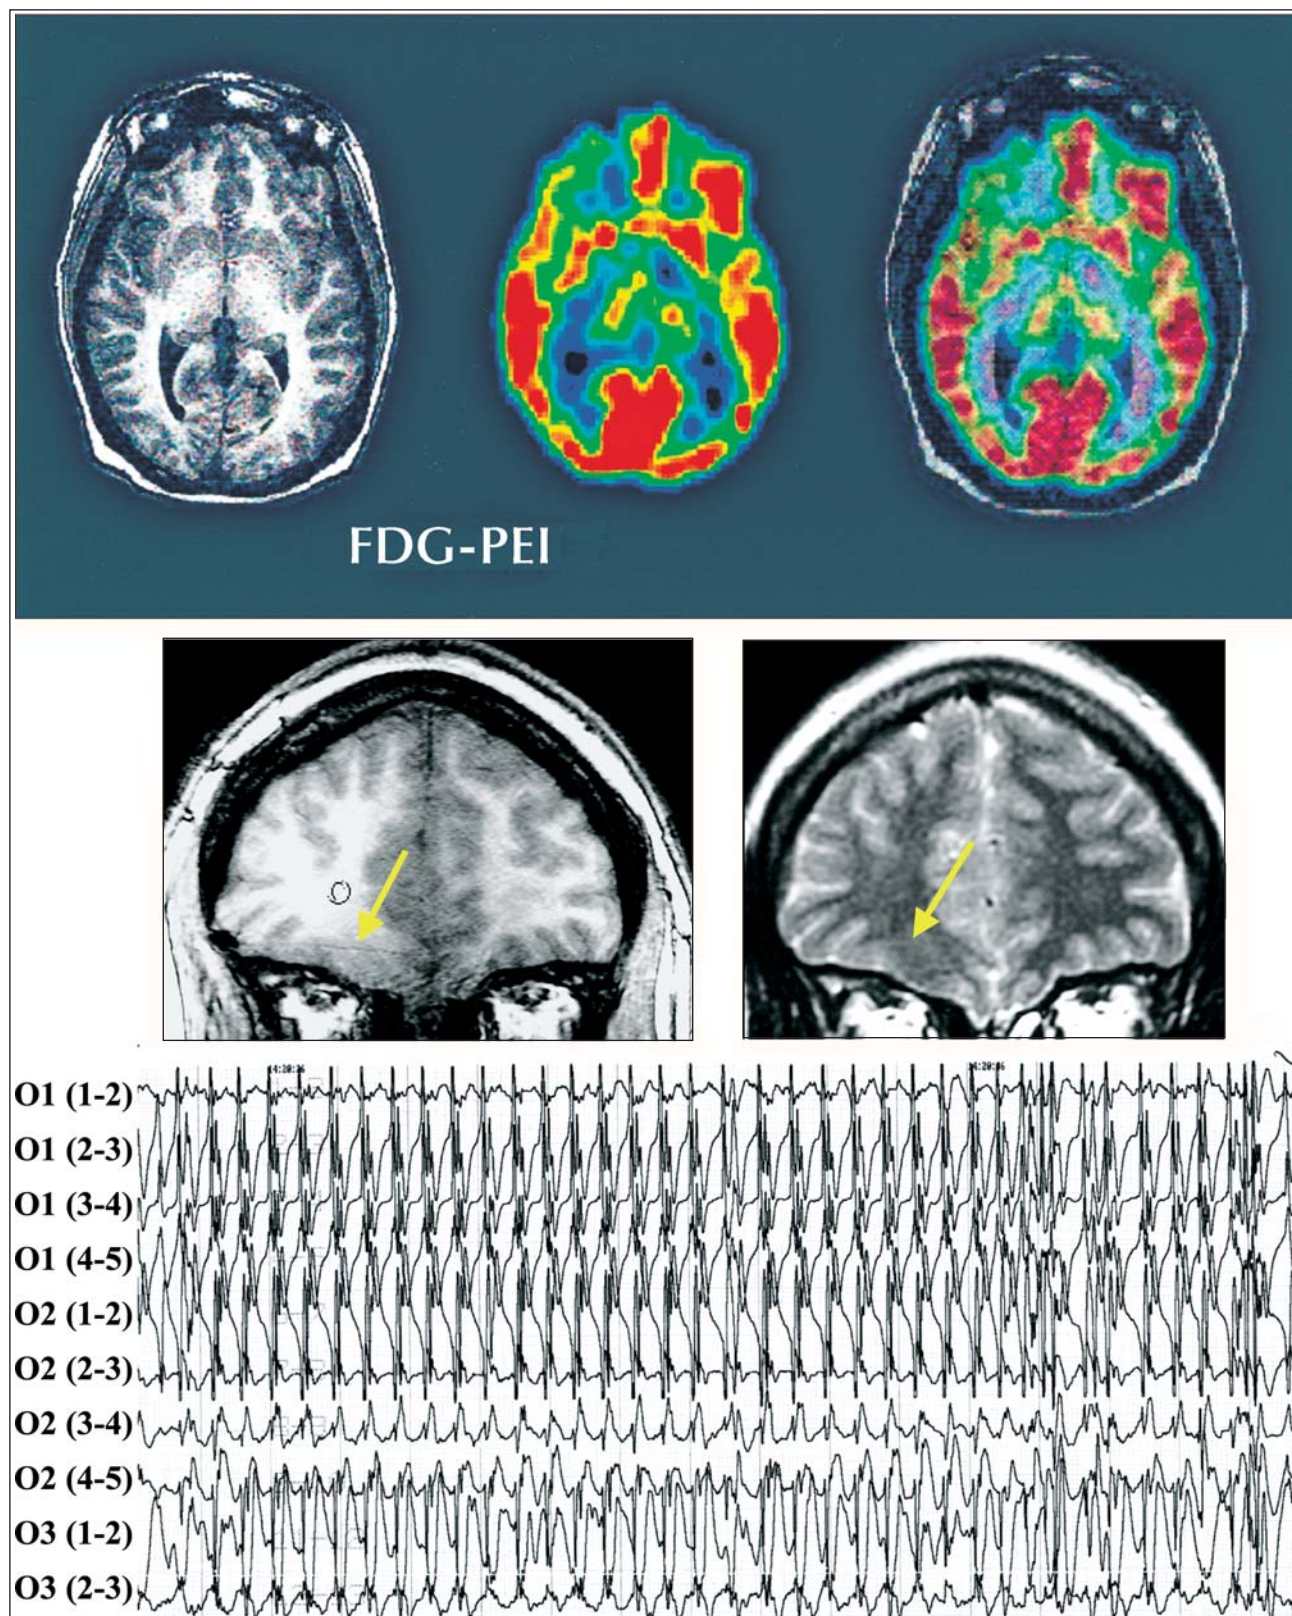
Case n°1; A. FDG-PET, axial slices: right orbito-frontal hypometabolism concordant with an area of poor demarcation between grey and white matter on MRI (SHFJ, CEA, Orsay).
